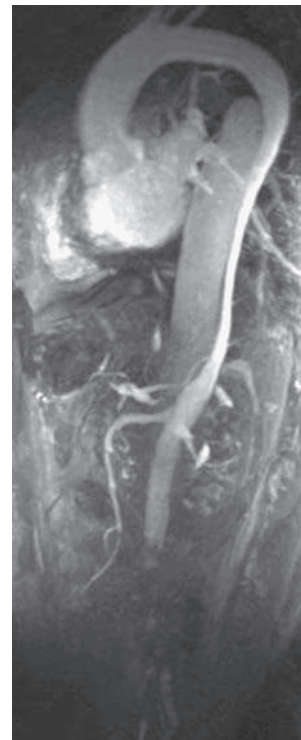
Magnetic resonance image of a type B dissection. (From Mulder BJM. The distal aorta in the Marfan syndrome. *Neth Heart J*. 2008;16:382-386.)
